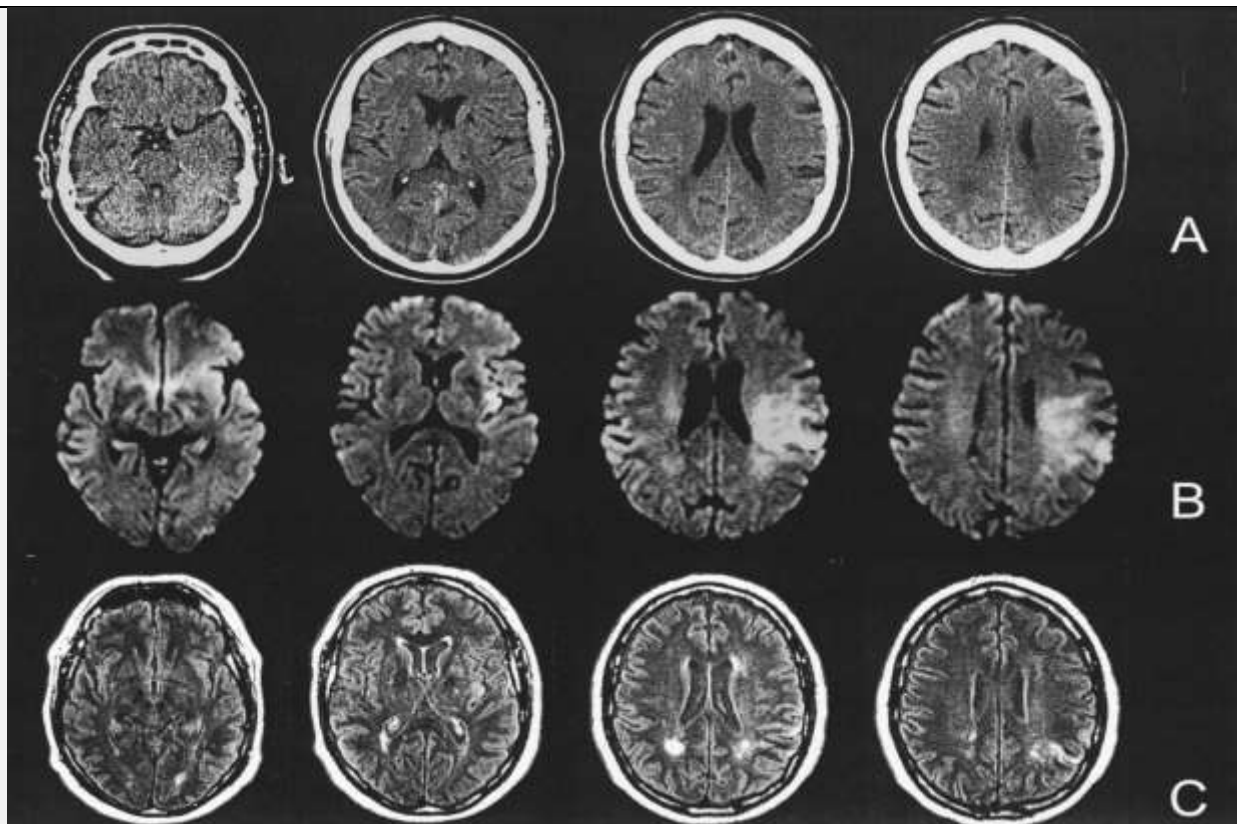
Case of a 62-Year-Old Patient with Aphasia and Right Hemiparesis. (A) CT Scans Obtained 100 Minutes after Symptom Onset, (B) DW Images Obtained 120 Minutes after Symptom Onset, and (C) Follow-up Flair Images. DW Images were Rated Positive by all Raters and Show Hyperintensity in the Left MCA Territory. CT Scans were Rated Normal by Five of the Six Raters. With the Knowledge of the DW Images, There Might be a Subtle Hypoattenuation in the Left Insular Ribbon Region on CT Scans. However, the Follow-up Flair Images Reveal Only Small Ischemic Lesions of the Left Insular Ribbon and Parietal Regions, with Normalization of Large Parts of the Former Diffusion-Restricted Area
